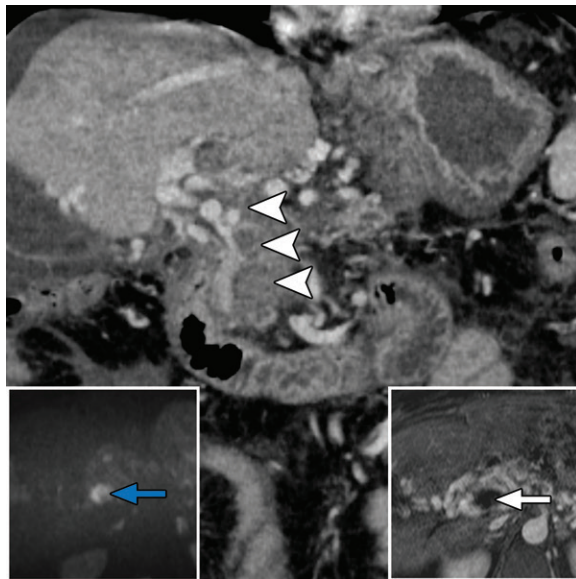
Thrombus evaluation with DWI in a 49-year-old man with necrotizing pancreatitis and reported portal vein tumor thrombus. Coronal contrast-enhanced CT image shows expansile soft-tissue-attenuating material (arrowheads) within the portal vein, which was interpreted as suspicious for tumor thrombus. Axial diffusion-weighted image with a b value of 800 sec/mm² (left inset) shows hyperintensity within the main portal vein (blue arrow), caused by either immobile protons within bland thrombus or dense cellularity within tumor thrombus. Axial T1-weighted portal venous phase subtraction MR image (right inset) shows nonenhancement of the portal vein (white arrow), the key finding used to distinguish bland thrombus in this case from tumor thrombus.
